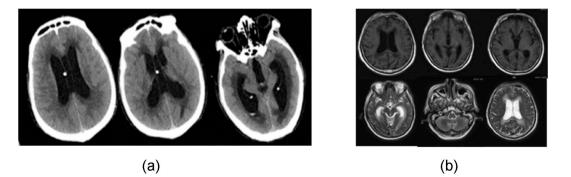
Imaging studies of patient 3. (a) Non-contrast computed tomography showing enlarged ventricular. (b) MRI showing abnormal signs with enlargement of the lateral ventricles. MRI-magnetic resonance imaging.
